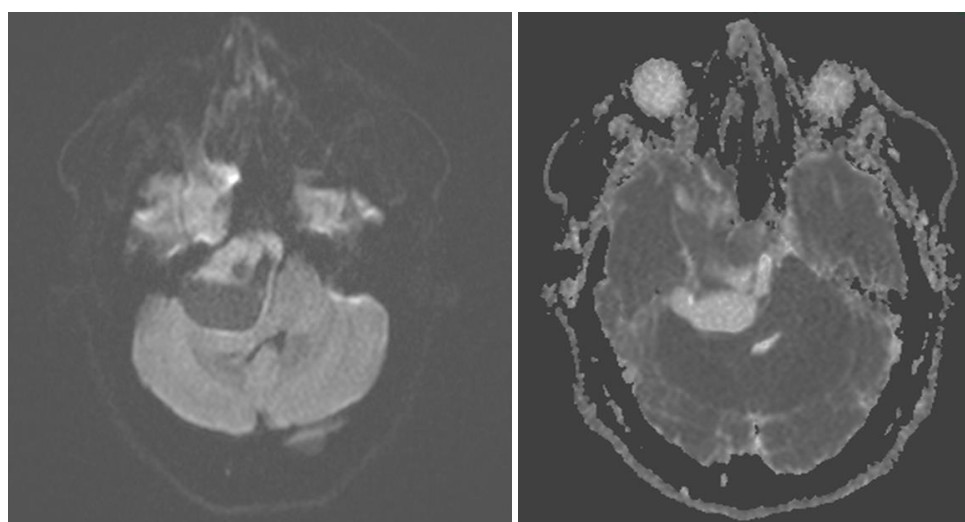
DWI sequences and ADC (Apparent Diffusion Coefficient) mapping show no diffusion hyperintensity within the lesion
